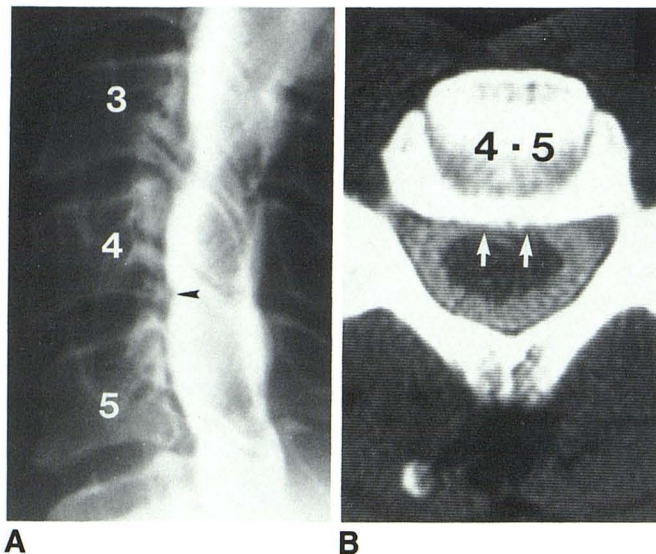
61-year-old patient with pain radiating down right arm into thumb. There was biceps weakness, and hypesthesia and hypalgesia in C5 and C6 dermatomes. A, Myelogram. Small ventral defect at C4–C5 (arrowhead) and larger impressions at C3–C4 and C5–C6 levels. B, CT myelogram at C4–C5 shows how CT can reveal subtle compromise of subarachnoid space. Ventral space attenuated centrally (arrows). Dorsal space is normal. C4–C5 and C5–C6 discectomies were performed with removal of osteophytes larger on right but significant in size bilaterally. There was postoperative improvement in pain and sensory deficits, with little improvement in biceps weakness.
